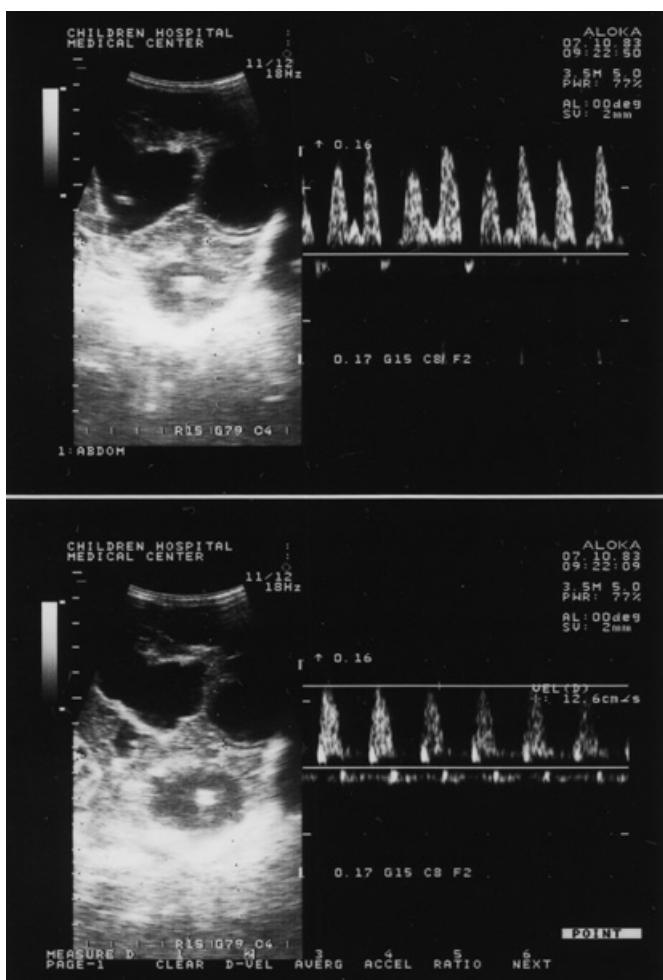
Doppler ultrasonography on admission confirmed a flow with a magnitude almost similar to that of the right MCA flow, inside the mass located adjacent to it.
